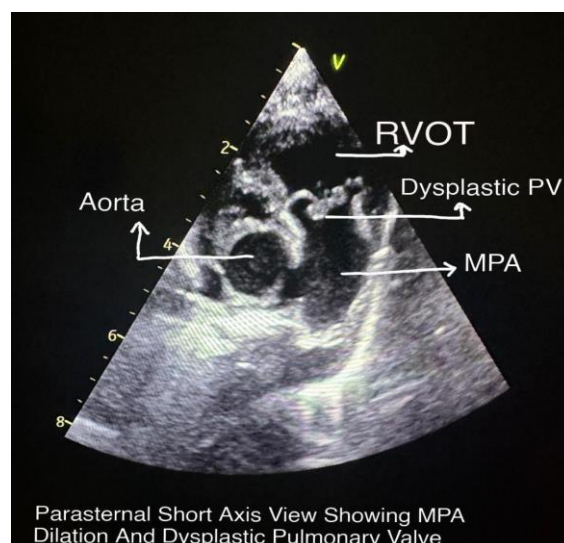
showing parasternal short axis view showing MPA Dilation and dysplastic pulmonary valve
